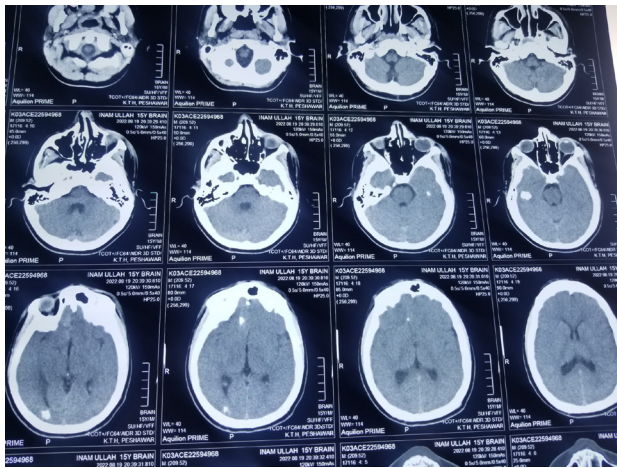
CT Brain Showing Subependymal Tubers
